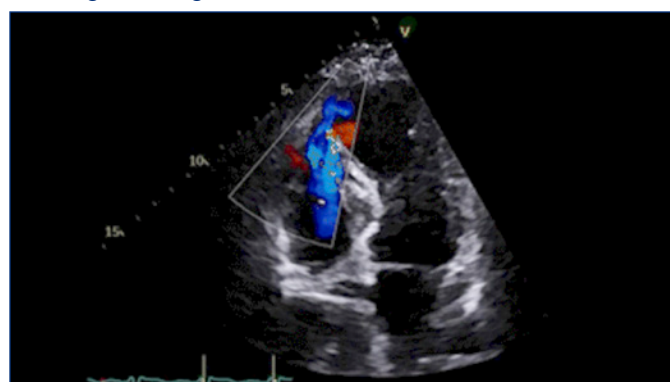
Clipped image of an apical four-chamber view showing a defect in the apical portion of the ventricular septum which shows left-to-right shunting.
